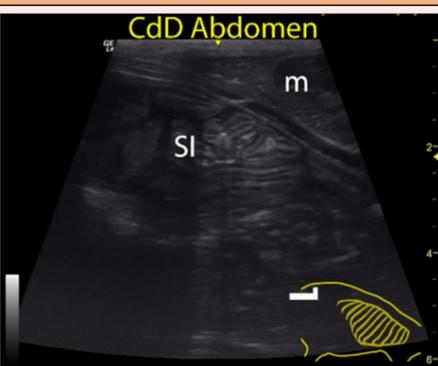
Ultrasonographic image of the small intestines. Cranial is to the left of the image. CdD, caudodorsal; SI, small intestine; m, muscle.
